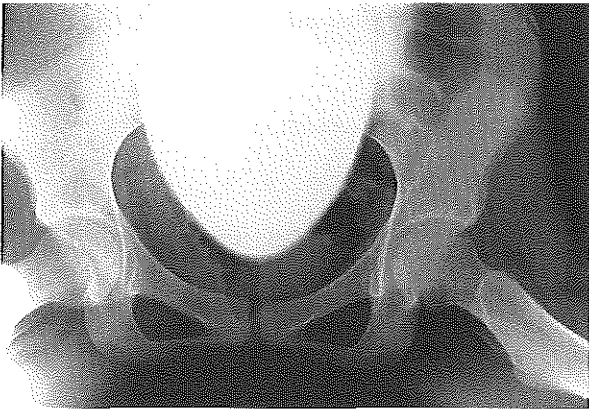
Radiograph of the hips was normal.
